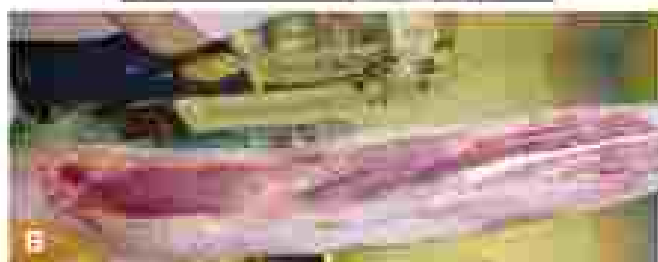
(A) Computed tomography scan shows the characteristic butterfly appearance of air in the muscle. Note the retracted femoral artery (arrow). (B) Note abnormal appearance of the muscle—exploration of arm muscle with dark necrosis and gas (light areas) with no bleeding from vertical incision that shows proximal and distal extension.
